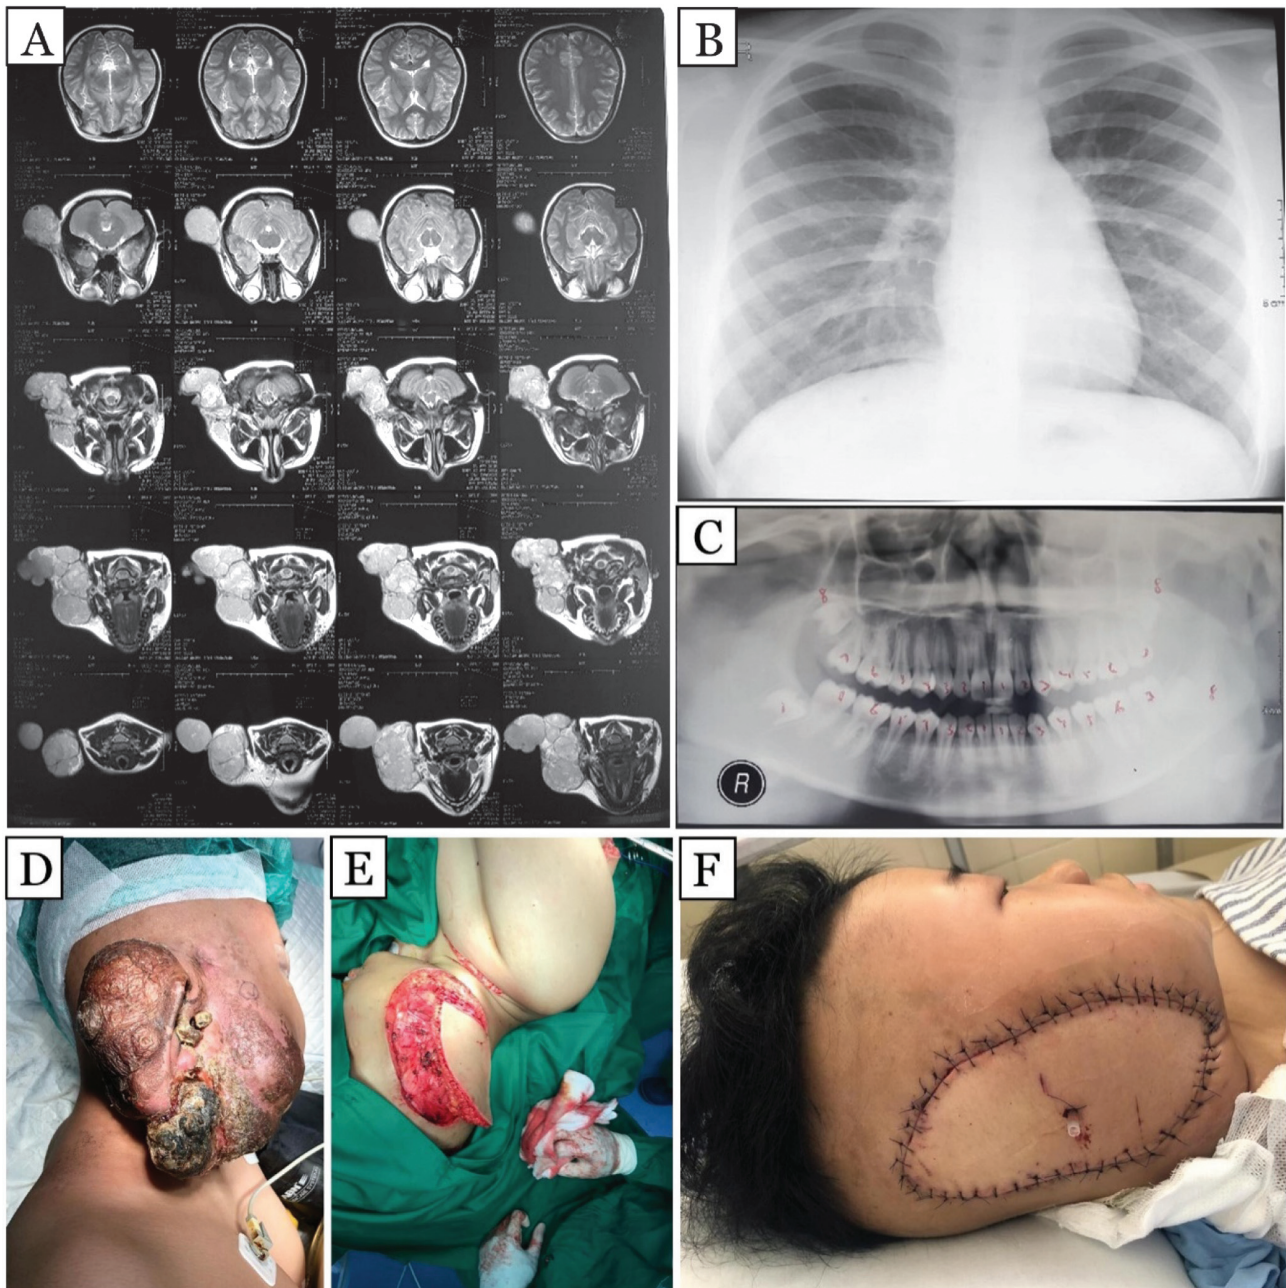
Patient 1. Radiological findings and surgical reconstruction of parotid region malignancy. (A) Brain magnetic resonance imaging (MRI) showing a mass at the right parotid region extending into the masticator space and infiltrating the right superficial masseter muscle, compressing the right maxillary artery. (B) Normal chest radiograph findings. (C) Panoramic radiograph showing no evidence of metastatic lesions. (D) Preoperative view showing an ulcerated tumor over the right parotid and temporal region. (E) Intraoperative view demonstrating tumor resection and harvesting of the latissimus dorsi flap. (F) Immediate postoperative result showing flap inset and closure.
